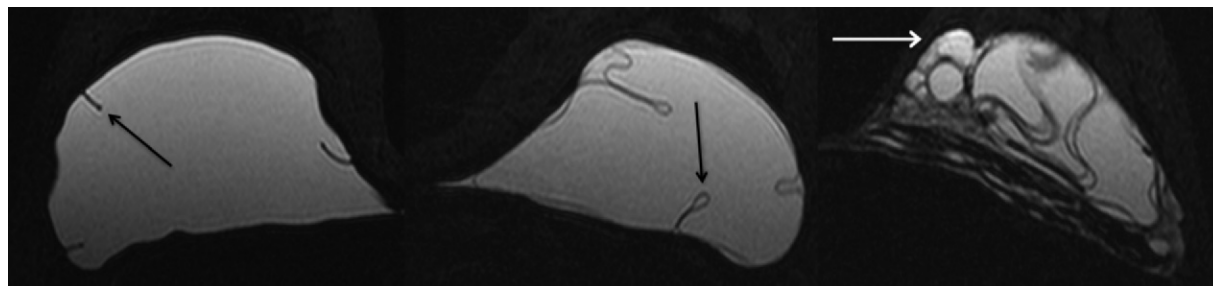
Implant findings. Although breast MR imaging has been used for evaluation of silicone gel implant integrity, the fifth edition is the first to include descriptors for implants. Axial silicone-specific water-suppressed MR images in a patient with both intra- and extracapsular rupture show intact implant radial folds (arrow in left image), intracapsular rupture with keyhole sign (arrow in center image), and extracapsular silicone in the breast (arrow in right image).
